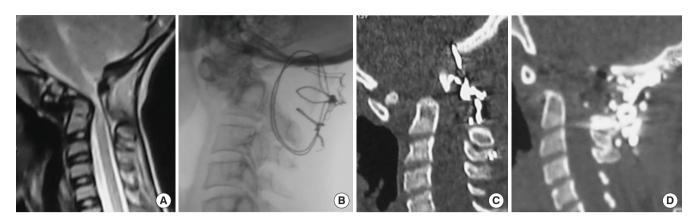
(A) A 22-year-old male (case 11, Table 1) sustained a type II dens fracture and suffered a fall from a rooftop 5.5 months ago while flying a kite. He underwent an unsatisfactory surgery elsewhere (wiring done posteriorly; B, C). Following our referral, the computed tomography also showed a fracture through one lateral mass of C1. (D) Thus, he underwent a modified distraction, compression extension, and reduction, which provided a satisfactory fracture reduction and realignment of the dens.
